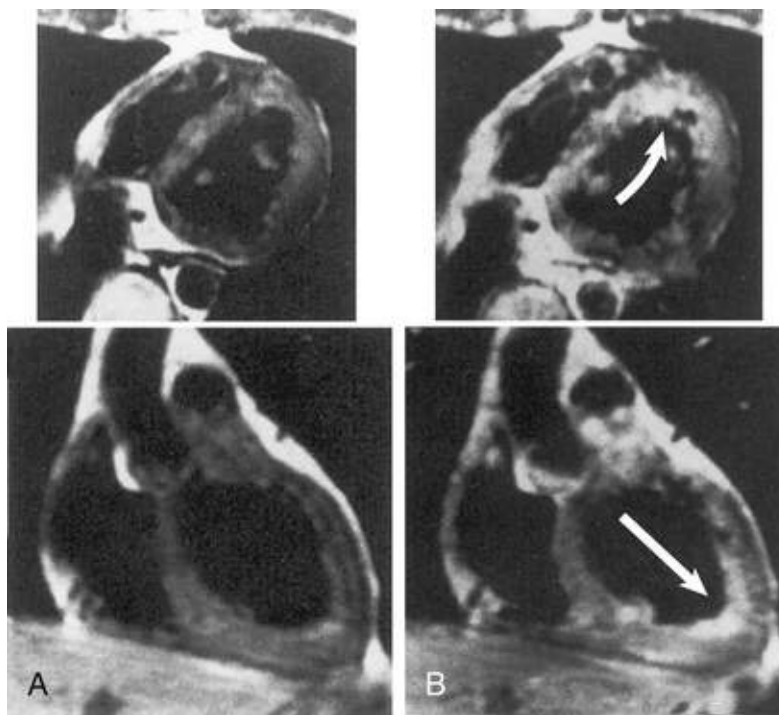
A, Precontrast T1-weighted transaxial (*upper*) and coronal (*lower*) magnetic resonance images through the left ventricle in a patient with myocarditis. B, Postcontrast magnetic resonance images at the same levels after injection of contrast material. Note enhancement of the myocardial signal in the septum and apical region (*arrows*). (From Matsouka H, Hamada M, Honda T, et al: Evaluation of acute myocarditis and pericarditis by Gd-DTPAenhanced magnetic resonance imaging. *Eur Heart J* 1994;15:283.)
